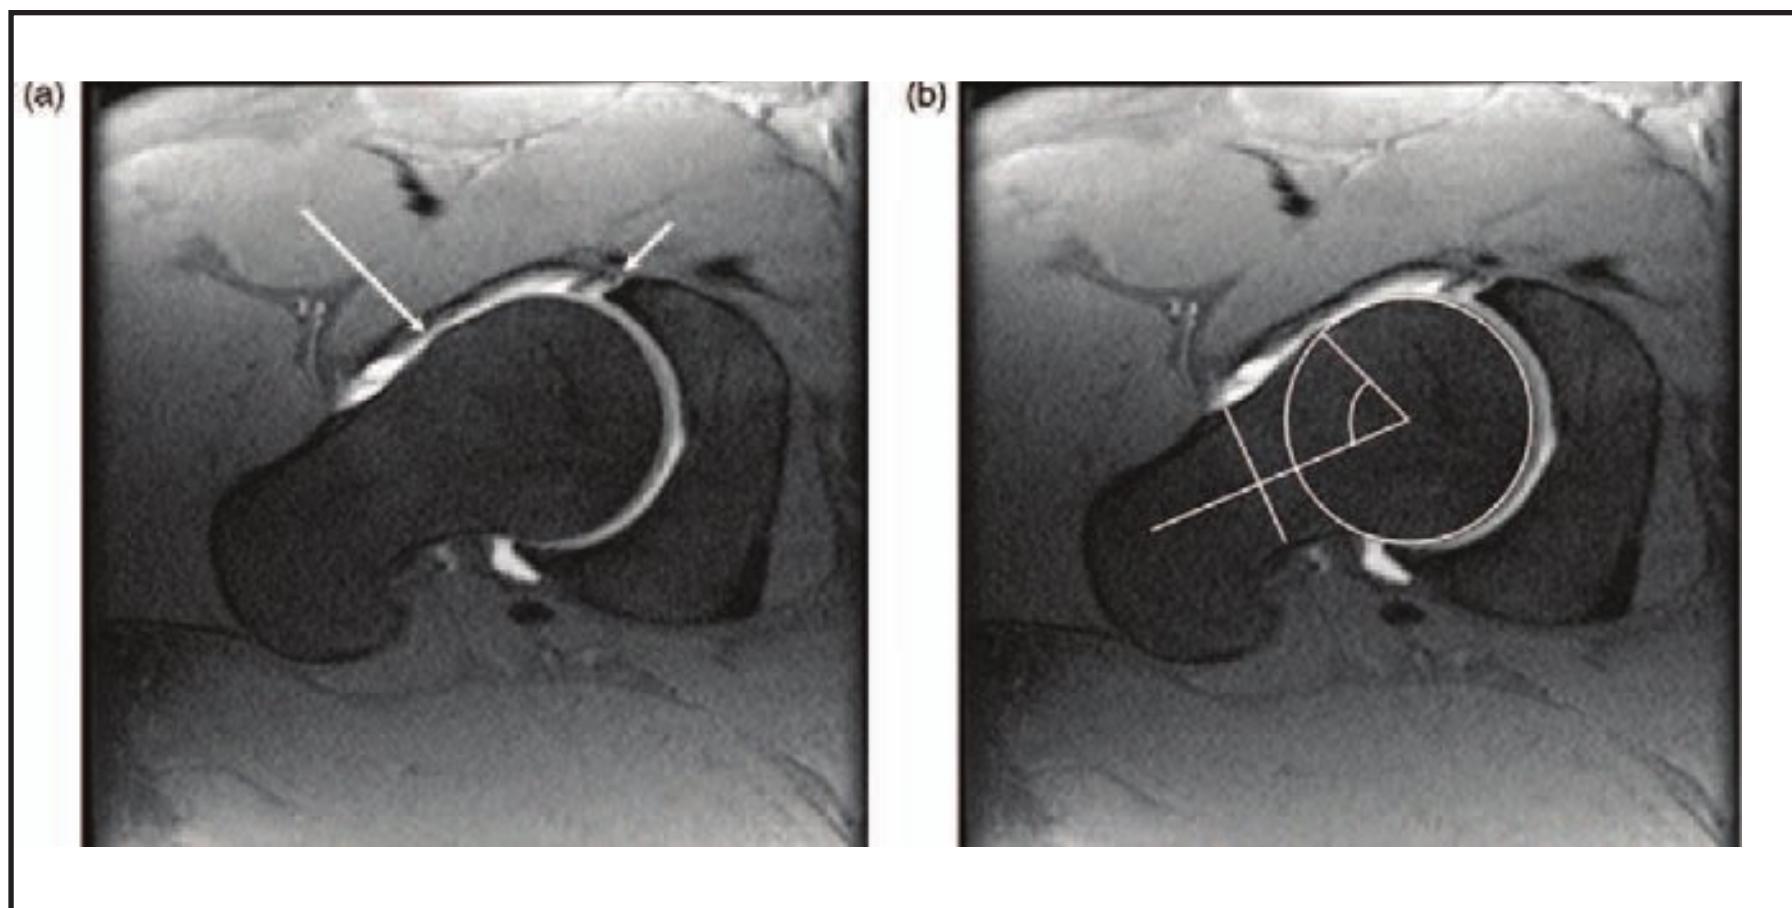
Oblique T1-weighted fat suppressed image shows abnormal anterior superior femoral head-neck offset and anterior superior labral tear and the lines used for measuring alpha angle. An angle greater than 55 degrees is considered abnormal.
